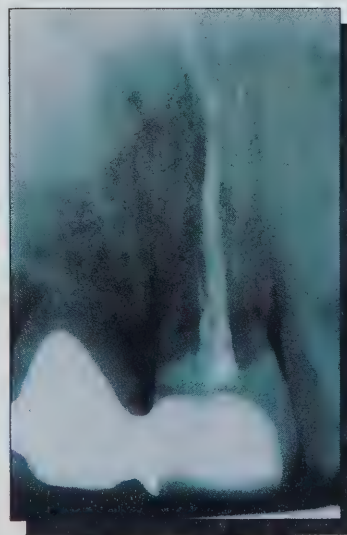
Radiograph of the maxillary left central incisor.
